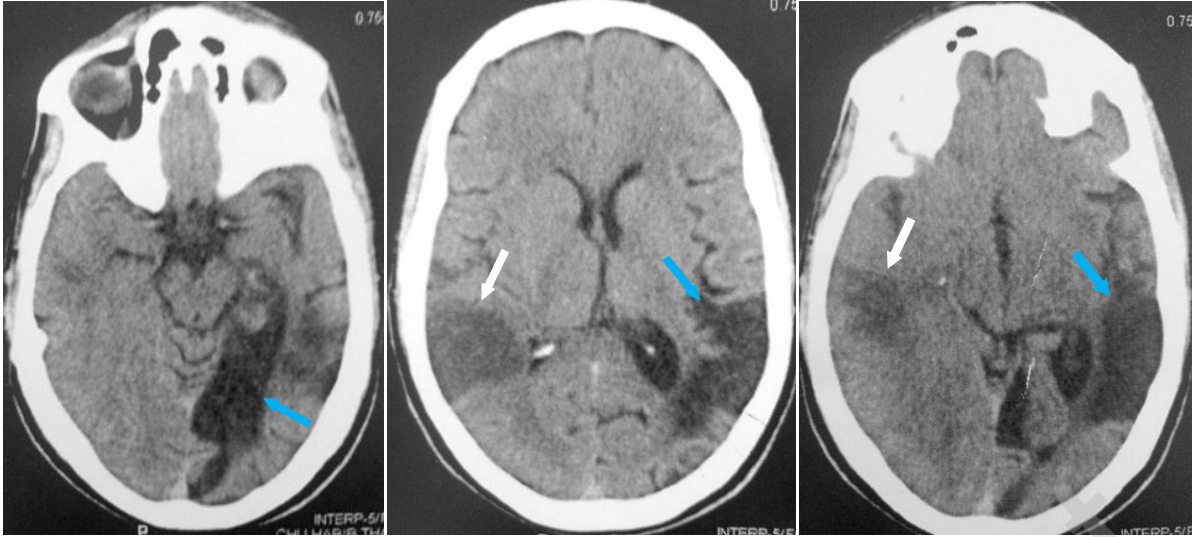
Brain Computed Tomography showing lesions of old ischemic stroke in the territory of the left posterior and middle cerebral artery (blue arrow) and a recent right middle cerebral artery stroke (white arrow).
